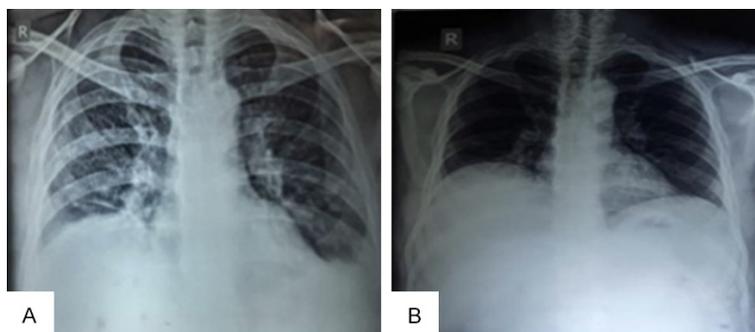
Comparative Chest Radiographs done on Day 1 and Day 14 showing complete resolution of opacities in bilateral mid & lower zones.
